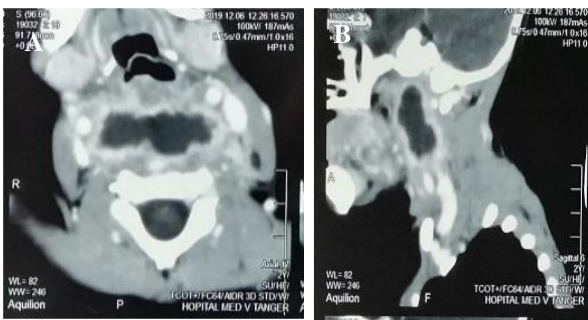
(A) Cervical CT scan with axial and (B) sagittal slices showing a hypodense image extending from C1 to C4 suggestive of a retropharyngeal median abscess.
